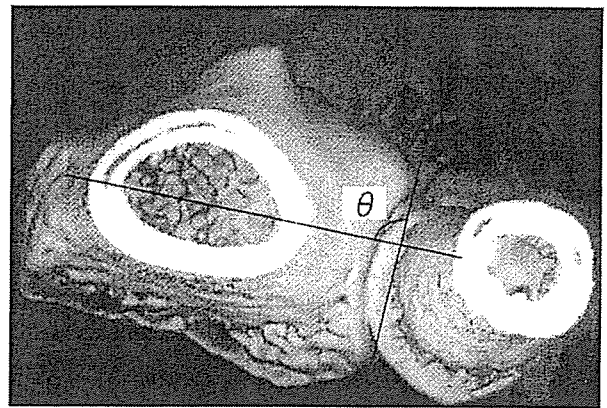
Pronation-supination deformity of the distal radius was determined by measuring the angle (θ) between the transverse axis of the radial shaft proximal to the site of malunion and a line tangential to the sigmoid notch of the radius from the helical CT scans at neutral rotation. The difference of the angle from the uninjured side was determined as the pronation-supination deformity. Positive = supination; negative = pronation.
